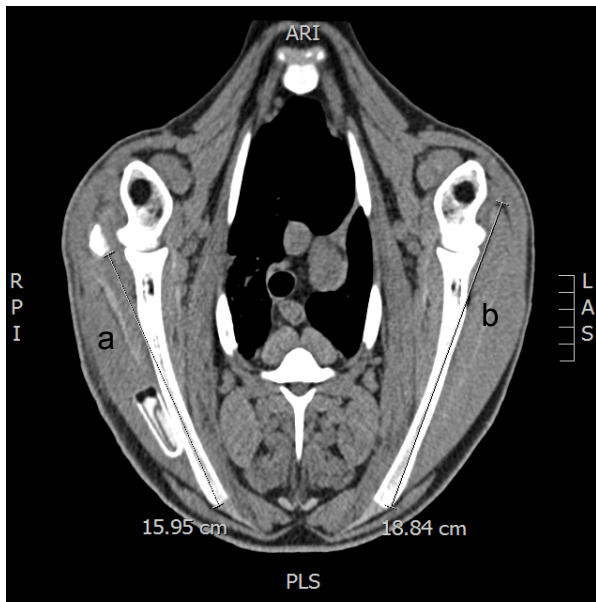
Transverse CT scan showing the measurements of muscle length on both sides: the OP side (a) and the CLAT side (b)
